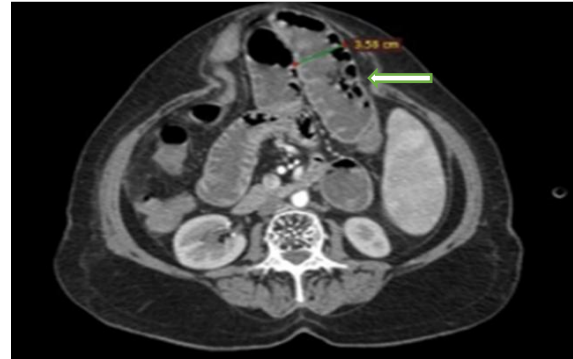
Axial contrast enhanced CT abdomen image showing anterior abdominal wall defect in the midline with dilated jejunal loops and mesentery as herniating content (white arrow) and multiple air-fluid levels, suggesting small bowel obstruction
